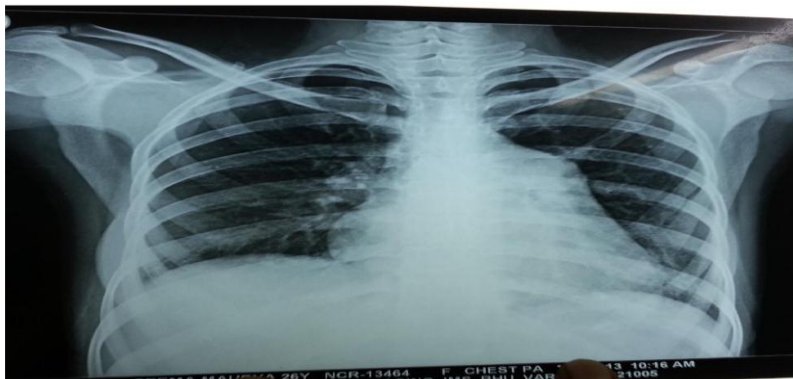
X-Ray Chest at the time of presentation showing the prominence of Right Pulmonary artery (before treatment)
